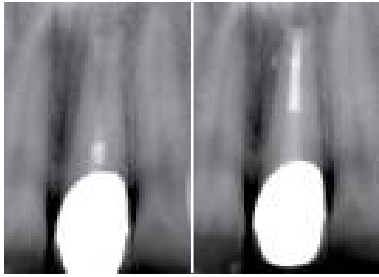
X-ray images of the treatment of an open apex
